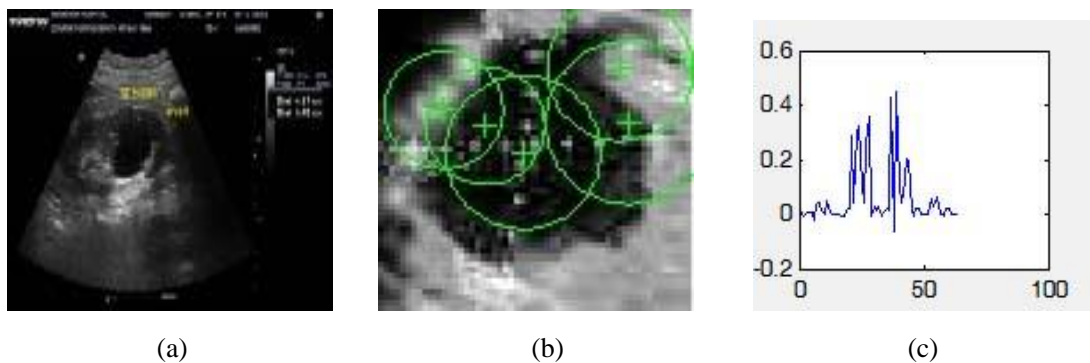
a) Ultrasound Kidney Image. b) SURF Key points. c) SURF features.
